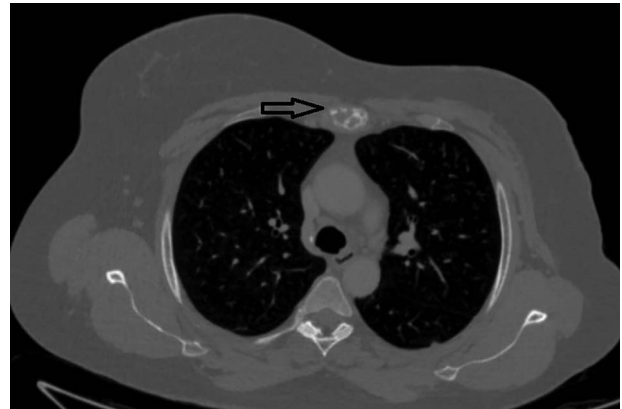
Lytic mid-sternal lesion on CT (arrow).
